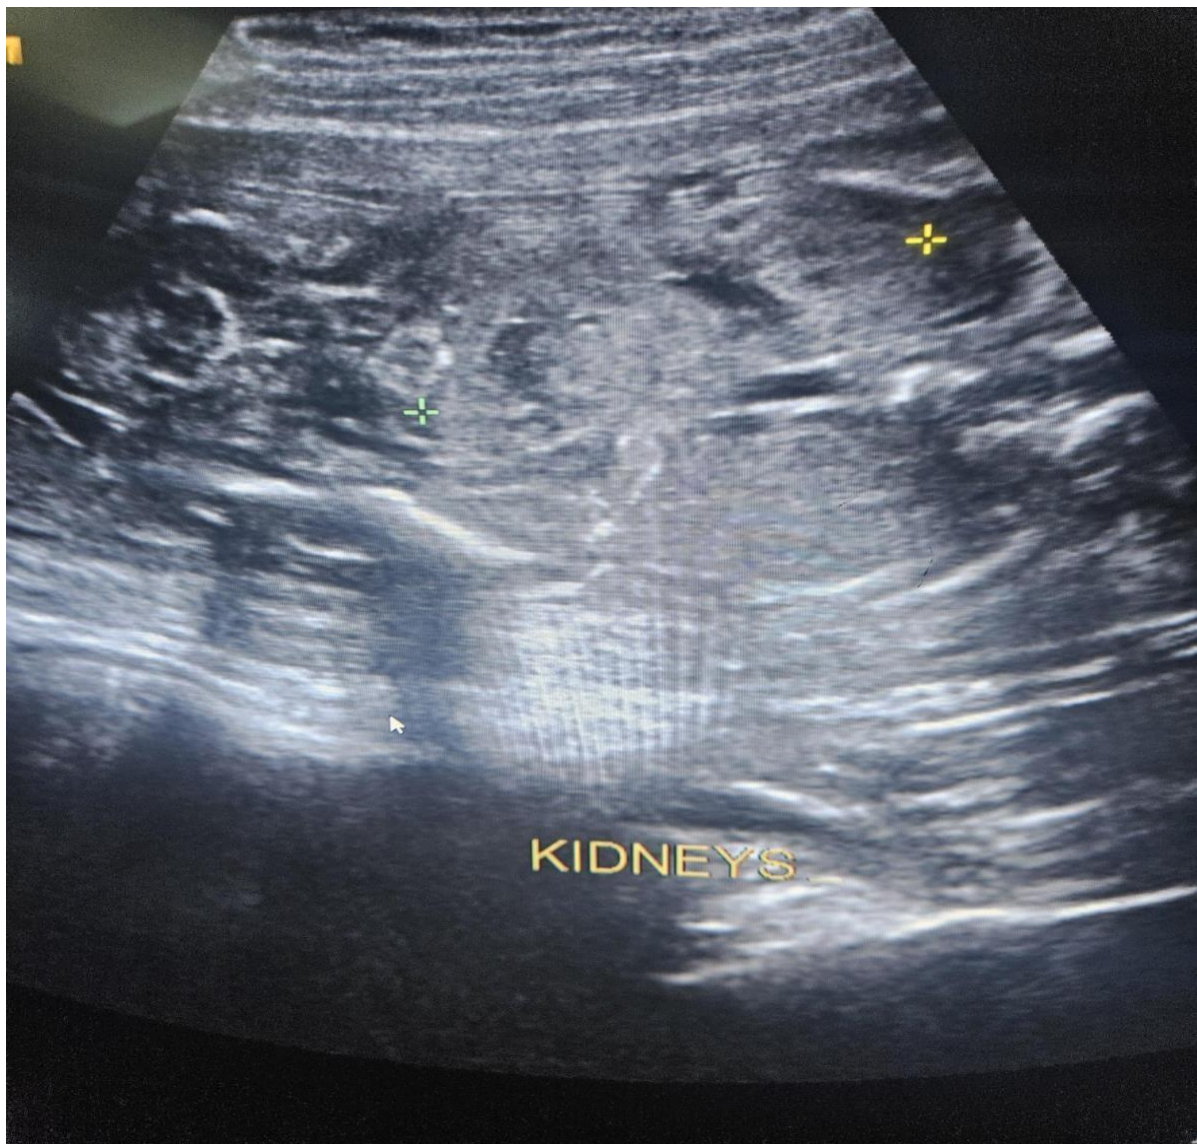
Case report, (Antenatal) Image Ultrasonography, Renal system nomaly scan at 21 weeks which revealed both kidneys seen in the left renal fossa fused with the left kidney.
